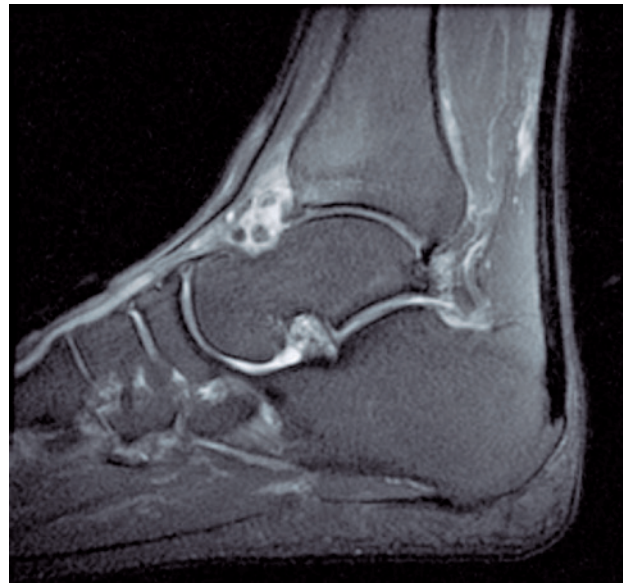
T2-weighted sagittal magnetic resonance image revealing osteophytosis in the anterior tibial articular border, joint chondral loose bodies, and synovitis.
